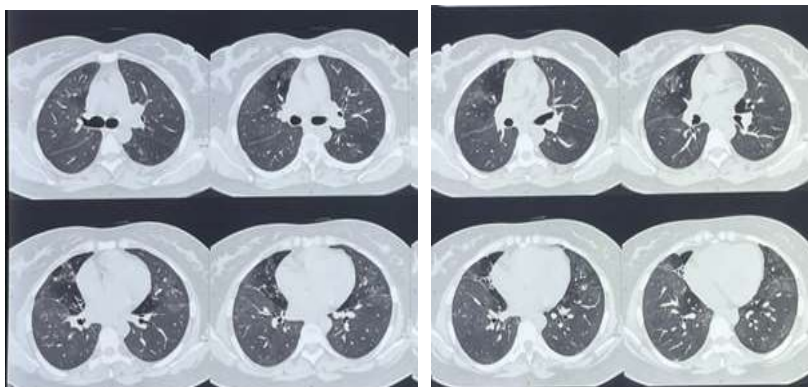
HRCT thorax showed bilateral extensive ground-glass opacities with right lower lobe bronchiectasis
